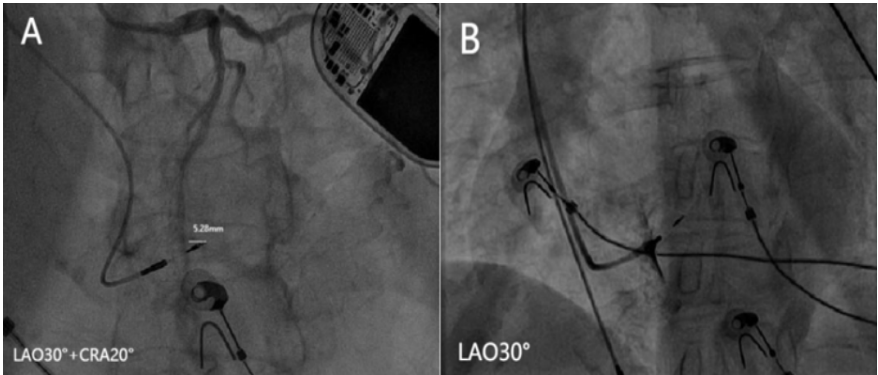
Image of the closest distance of the tip of the pacing electrode to the coronary artery. (A) Distance from the tip of the electrode to the anterior descending artery 5.28 mm. (B) C315 His intrathecal angiography shows no vascular scintigraphy.
